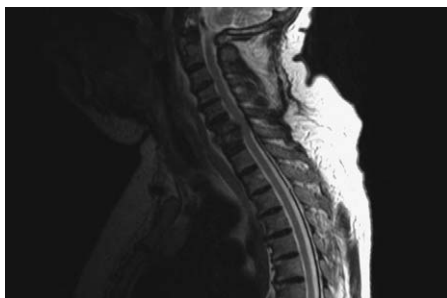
Central nervous system infections can present without fever or neurologic signs in elderly patients. This is a sagittal MRI image of the spine in a 73-year-old woman who presented to the emergency department with a sole complaint of neck pain. This image reveals C6/7 osteomyelitis and discitis with epidural extension resulting in spinal cord compression.
